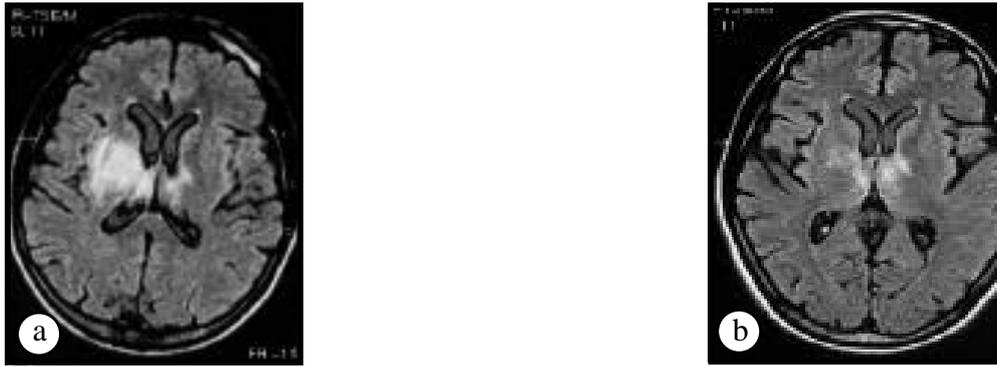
Fluid attenuated inversion recovery MRI showing a) hyperintense signal in the right basal ganglia (internal capsule, both thalami, upper midbrain and both cerebral peduncles. b) the hyperintensity signal seen in the former MRI has been significantly reduced in size.
